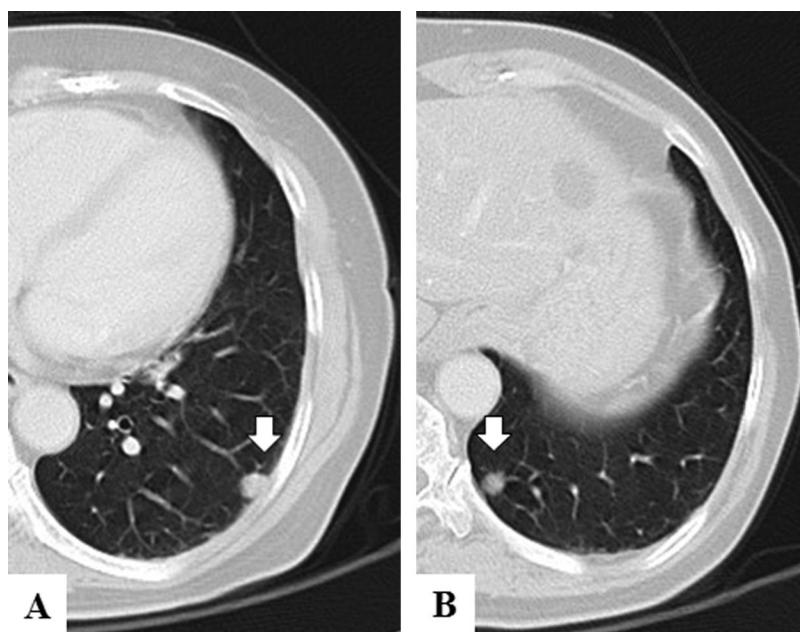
Chest CT image of the left lower lobe (S9) shows a solid density with a regular margin, and the size is a 10 \times 10 mm (A). CT image of the left lower lobe (S10) shows a solid density with a focal irregular margin on the lung window, and the size is a 8 \times 8 mm (B).
